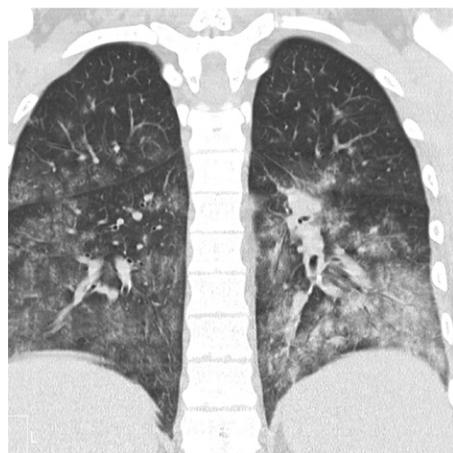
Coronal CT reformatted image in a 48-year-old man with a history of SARS shows multifocal bilateral ground-glass opacities, acinar ground-glass nodules, and left lower lobe consolidation. Note the absence of pleural effusions.
